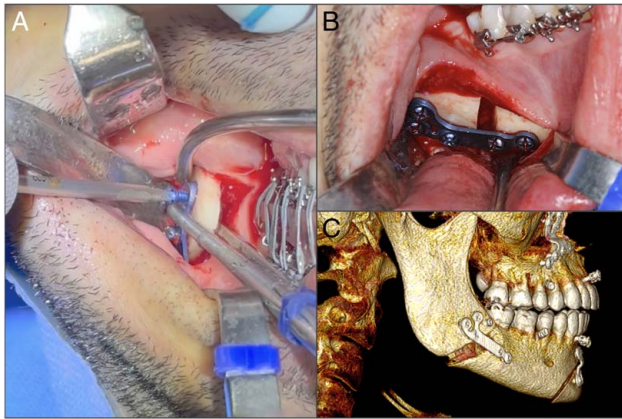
(A) Transoperative view during insertion of the monocortical locking screw. Note the superior and anterior angulation of the plate, which allows easy insertion through an intraoral minimally invasive approach. (B) Mandibular advancement after fixation with 5 monocortical locking screws using a stronger plate. (C) Immediate postoperative 3D CT reconstruction showing the position of an additional conventional bicortical screw. 3D indicates 3 dimensional; CT computed tomography.
